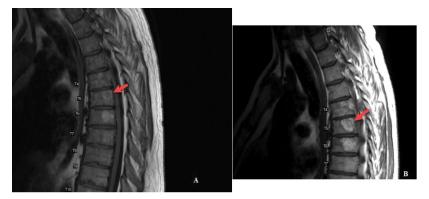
A: A 49-year-old man with metastatic myxoid liposarcoma. Sagittal T1W MRI without contrast demonstrating a lesion with increased signal intensity at T5 (Red arrow). This is an atypical pattern for a metastatic myxoid liposarcoma. B: A 49-year-old man with metastatic myxoid liposarcoma. 9 months later, Sagittal T1W MRI without contrast demonstrating an increase in T1 signal intensity with interval increase in size (Red arrow)
